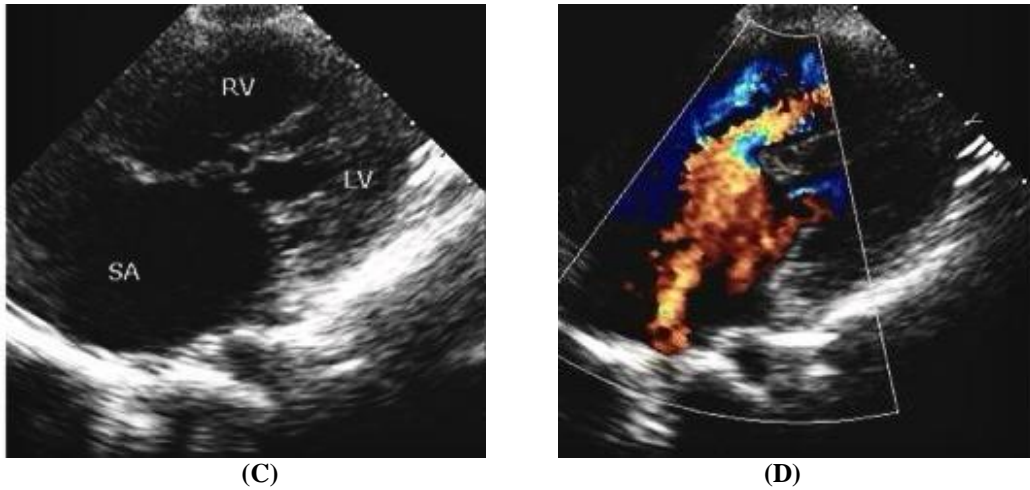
Transthoracic color echocardiography. (A) Echocardiography Doppler showing an ostium primum atrial septal defect with a right-to-left shunt. (B) Echocardiography: apical view with color doppler depicting grade III mitral regurgitation. (C) Subcostal view shows single atrium; (D) Color Doppler imaging depicts left to right shunt across the defect; SA , single atrium; RV, right ventricle; LV, left ventricle.
